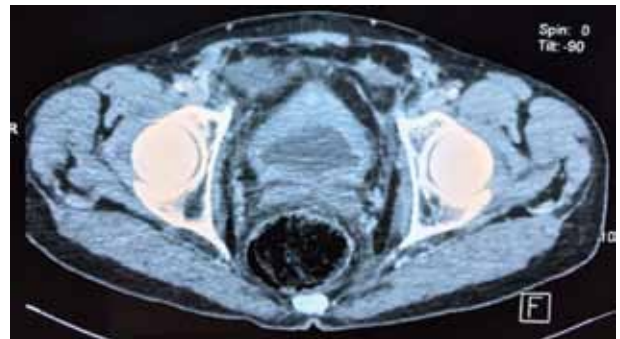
Pelvic CT: regular thickening of the anterior wall of the bladder
